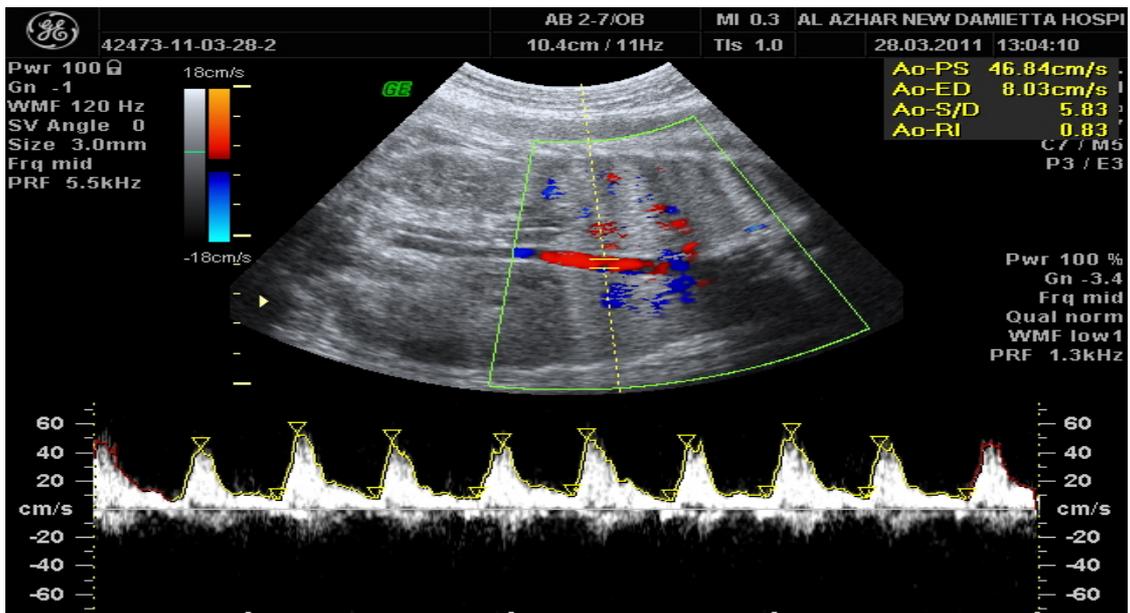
Doppler velocimetry of fetal descending aorta at 36weeks.
